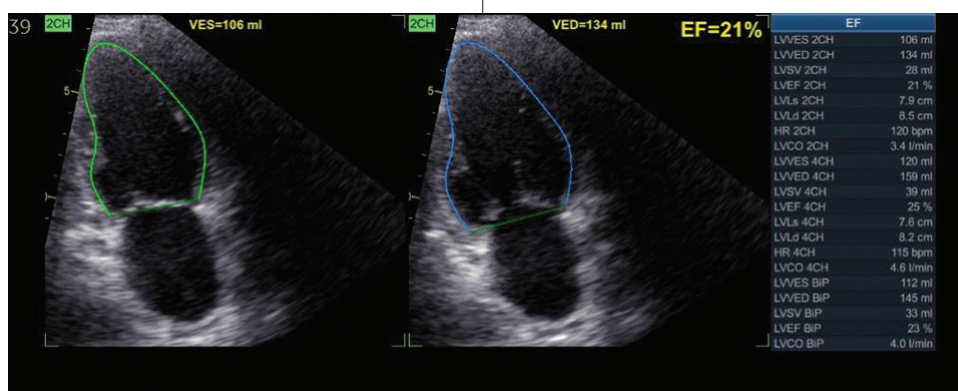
Echocardiography after coronary revascularization showing a severely reduced ejection fraction of 21%; cardiac index 2.1 L/min/m².
